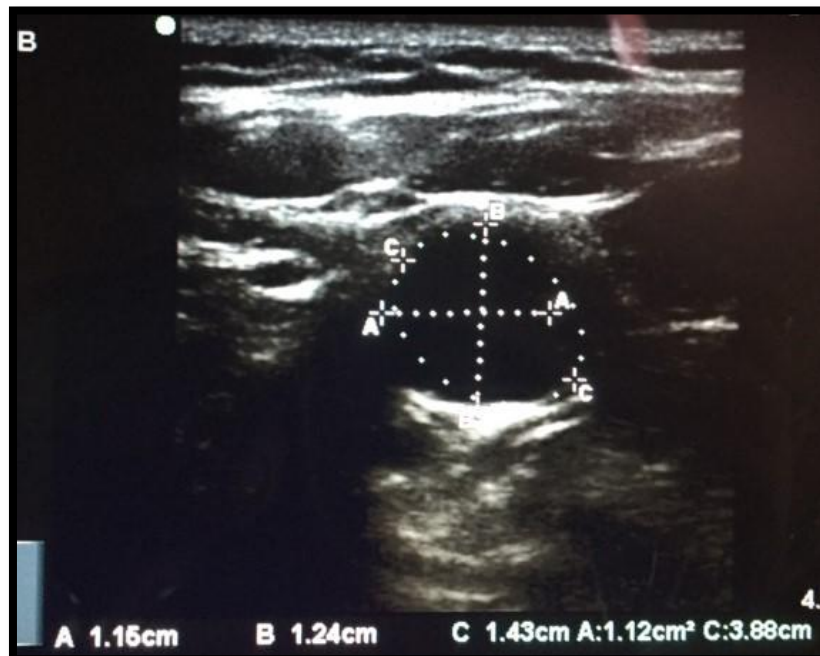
SP₀ – Ultrasonographic image showing RIJV at supine position with no PEEP (SP₀)
